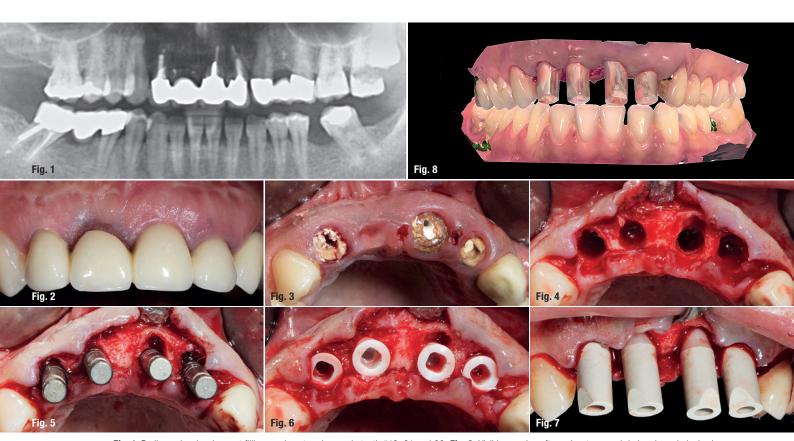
Radiographs showing root fillings and post-and-cores in teeth #12, 21 and 22. Fig. 2: Visible scarring after apicectomy and dark-coloured gingiva in region #11. Fig. 3: Secondary caries in the hopeless abutment teeth. Figs. 4–6: Immediate implantation of two-piece zirconia implants in regions #12, 11, 21 and 22. Figs. 7 & 8: An intra-op digital impression of the two-piece implants was taken.
